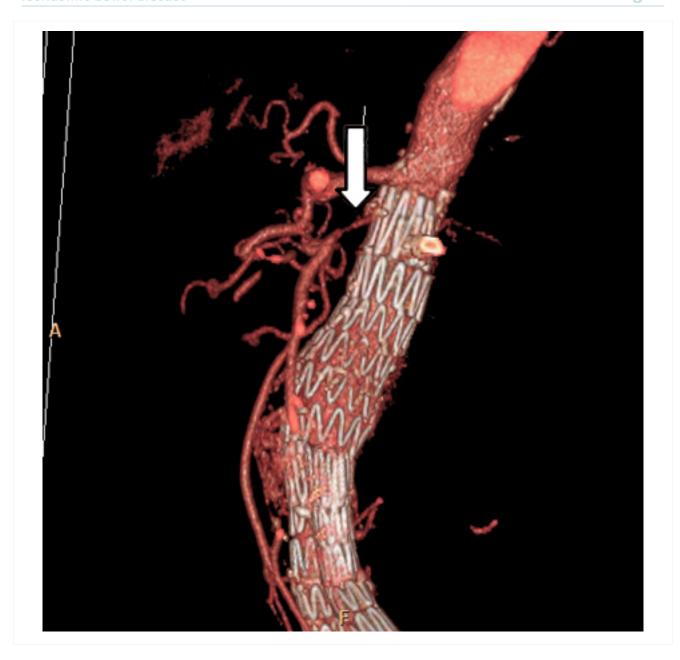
CT angiography: 3-dimensional reconstruction with superior mesenteric artery stenosis from severe atherosclerotic plaque in a patient on follow-up imaging for endovascular aneurysm repair
